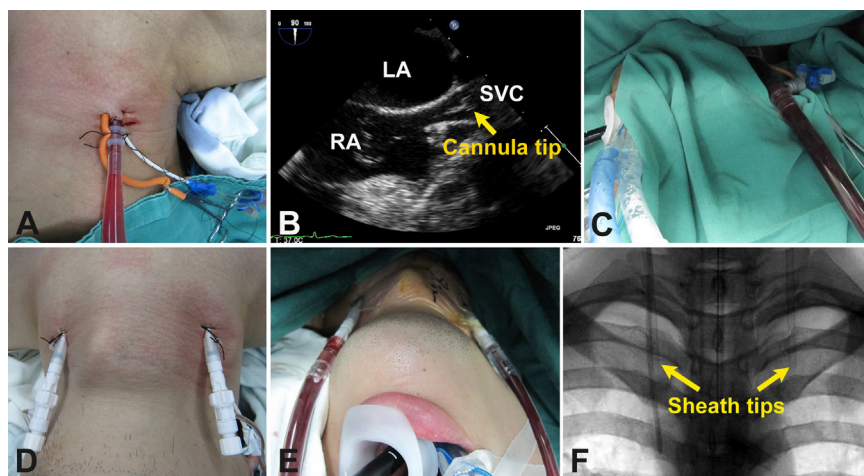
Superior vena cava drainage with PSVC cannula and BIJV sheaths. (A) A 14-18 Fr cannula was inserted into the superior vena cava via the right internal jugular vein. (B) Transesophageal echocardiography was used to position the cannula tip at the right atrium/superior vena cava junction. (C) Venous blood was drained from a connected 3/8 inch tubing. (D) Two 8 Fr sheaths were inserted into the BIJVs. (E) Venous blood was drained from 2 connected 1/4-inch tubings. (F) The position of sheath tips was confirmed near the sternoclavicular notch with a chest x-ray. PSVC, percutaneous superior vena cava; BIJV, bilateral internal jugular veins; LA, left atrium; RA, right atrium; SVC, superior vena cava. (Color version of figure is available online.)
